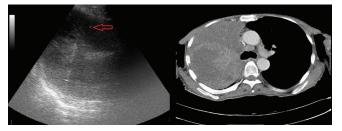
Thoracic USG-guided TTTCB procedure in a patient with peripherally located tumor in the right lung in a thoracic CT. (Sonographically a 10x9 cm hypoechoic lesion, the tru-cut biopsy needle is marked with a red arrow)
